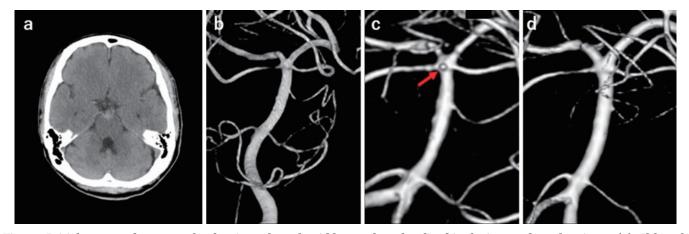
Initial computed tomography showing subarachnoid hemorrhage localized in the interpeduncular cistern (a). Although three-dimensional rotation angiography (3D-RA) revealed no vascular anomaly on admission (b), 3D-RA on Day 9 revealed a small aneurysmal change (arrow) of approximately 1 mm in the dorsal basilar artery (c). 3D-RA on Day 42 revealed complete disappearance of the lesion (d).
